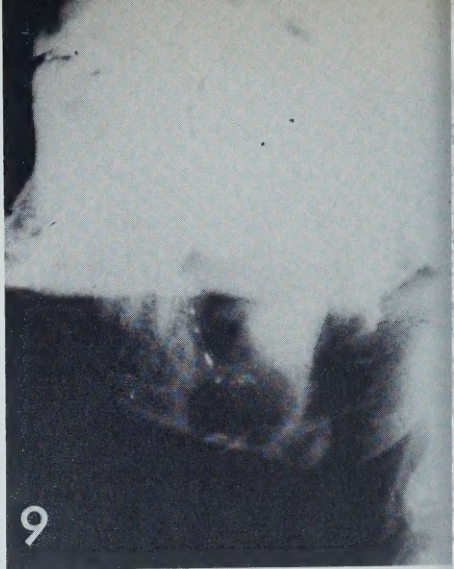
Post-operative right oblique radiograph of mandible.
